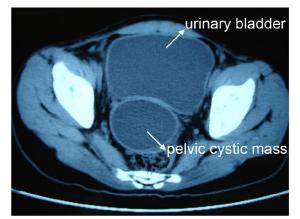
A cystic mass behind the urinary bladder was showed in CT.
